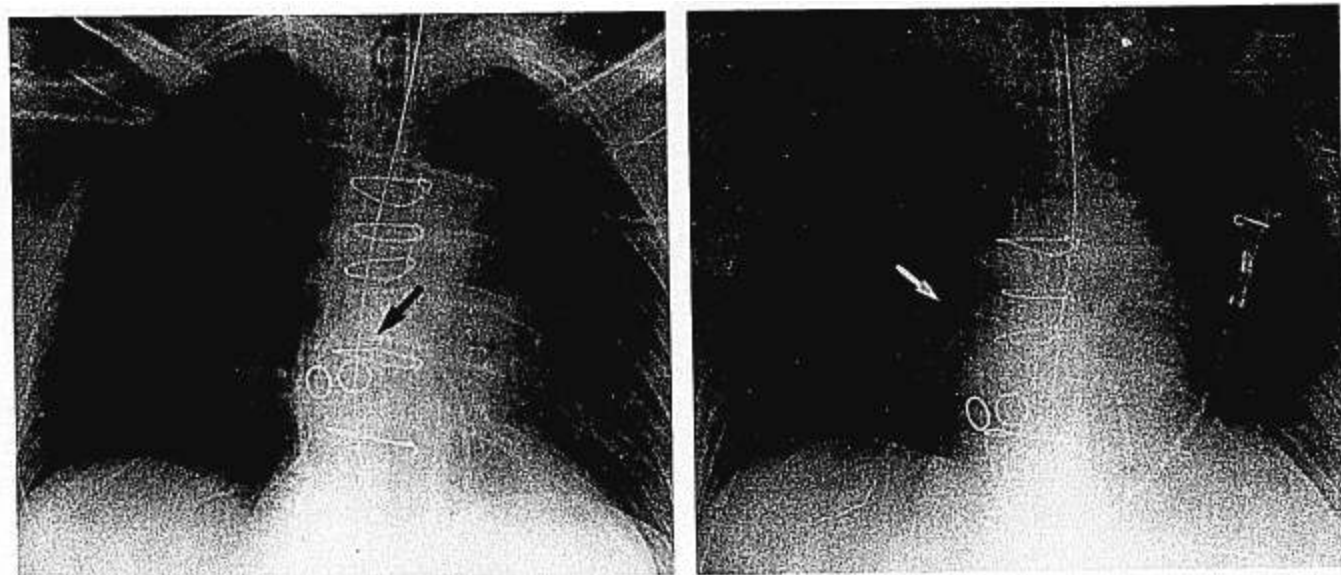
Chest radiographs of a patient before (A) and after (B) unsuspected distal catheter migration; arrows indicate the catheter tips. The middle lumen of the catheter transduced a right ventricular waveform (A) and pulmonary artery waveform (B). After radiograph B was taken, the catheter was pulled back as needed (3 cm) so that the middle lumen transduced a right ventricular waveform.
